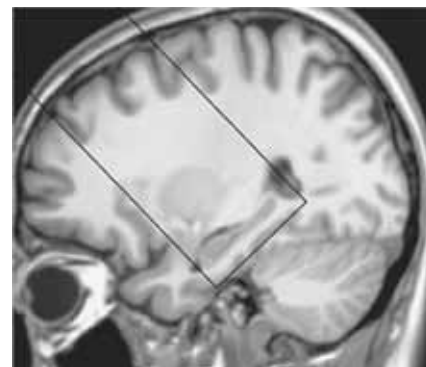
Image shows arterial spin labeling (ASL) perfusion imaging slab position. The oblique coronal ASL imaging sections were positioned to cover the head of the hippocampus, with the inferior edge of the imaging slab parallel to the longitudinal anteroposterior axis of the hippocampus and tangent to the gyrus of the temporal lobe, by using T1-weighted high-resolution anatomic images for accurate reference.
